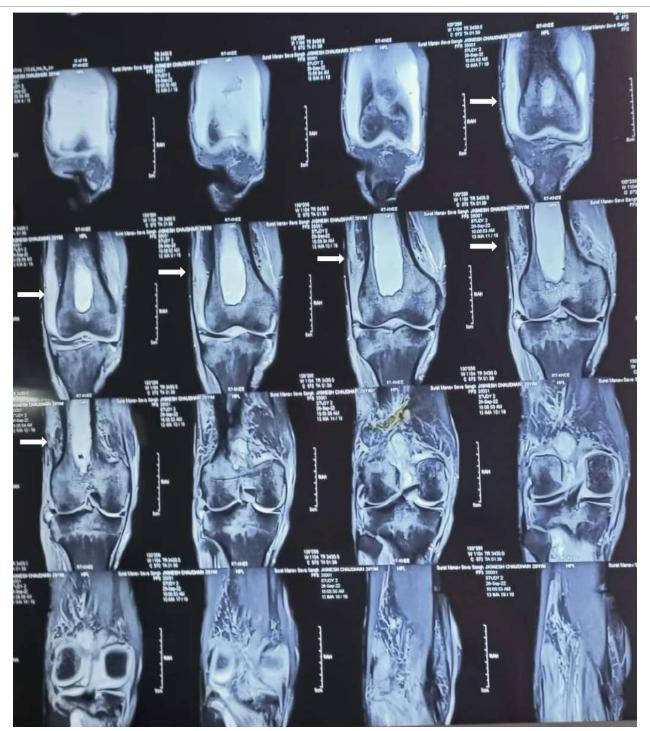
MRI findings suggestive of intramedullary abscess formation
